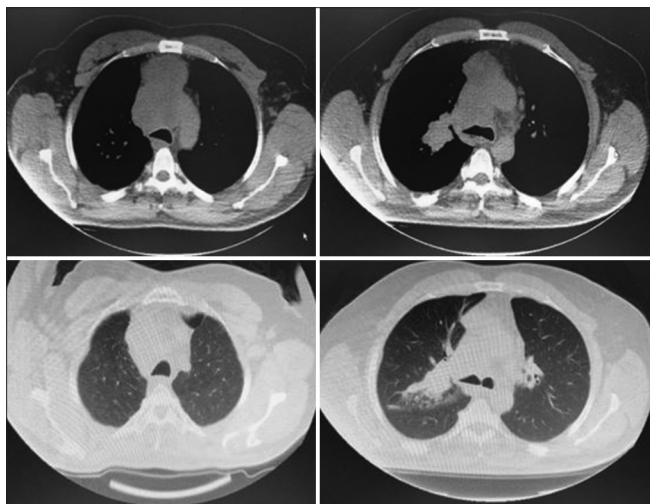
Thorax computed tomography detected a 7 cm × 3.5 cm irregular mass lesion displacing the superior vena cava extending to the paratracheal area posteriorly in the anterior mediastinum
